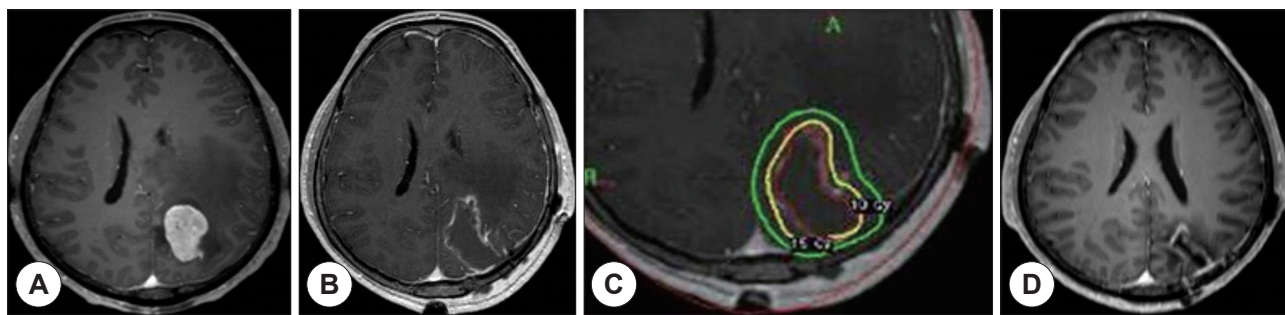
CASE M/50 lung cancer. A 50-year-old man with known lung cancer. Complete resection was performed, and he underwent radiosurgery. At the follow-up MRI (1.5 years), he had no local recurrence. Axial contrast enhanced T1-weighted magnetic resonance imaging scans before resection (A), Post-resection T1Gd Gamma Knife MRI (B), Gamma Plan snapshot at the time of radiosurgery (C), and 18 months after radiosurgery (D).
